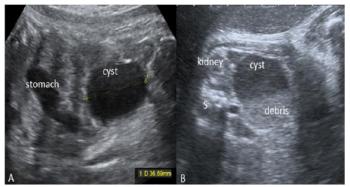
Ultrasound images of fetal ovarian cysts.
